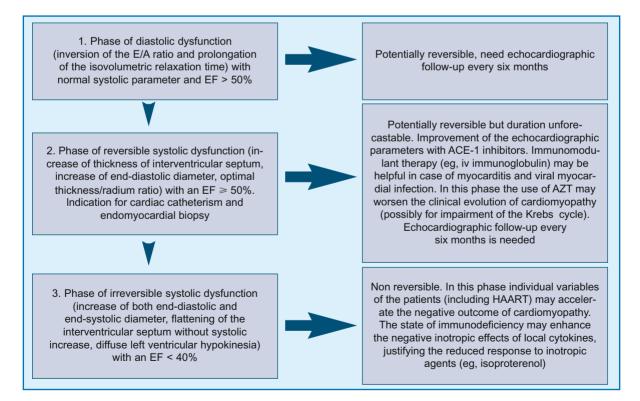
Echocardiographic classification of HIV-associated cardiomyopathy with related clinical implications
